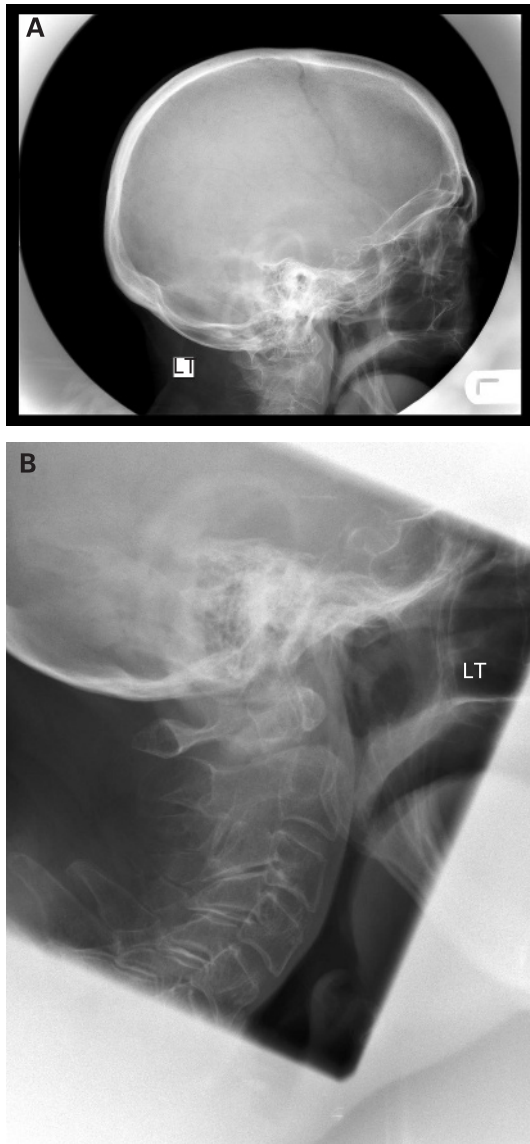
(A) Lateral skull radiograph taken as part of an assessment in a 90-year-old woman who had fallen on her face. Careful review of the whole image revealed a fracture to the odontoid peg. (B) Lateral C-spine view taken later clearly showing the C2 fracture with substantial displacement.
